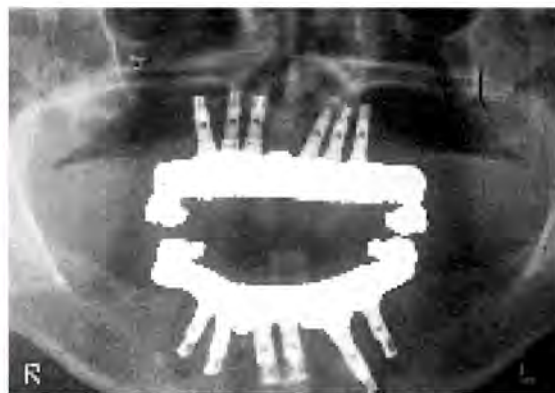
Panoramic radiograph of the final prosthesis.
